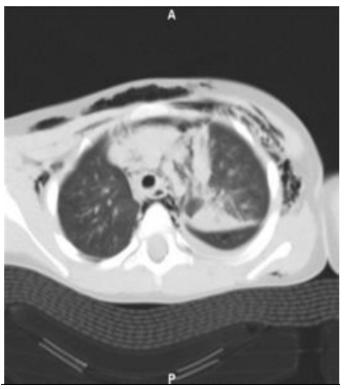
CT Scan showing emphysematous bullae in sub-pleura and lung parenchyma
